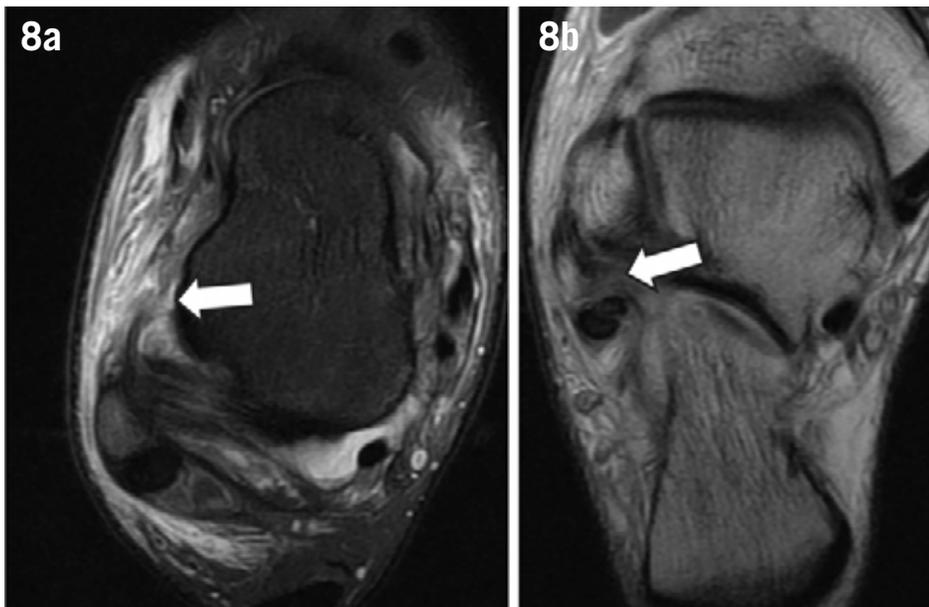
Magnetic resonance imaging of an injury affecting the lateral ligaments of the ankle. Axial T2 weighted image with fat saturation depicting a complete discontinuity of the anterior talofibular ligament near the talar attachment (arrow) and coronal oblique PD weighted image (b) depicting a nearly complete tear of the calcaneofibular ligament (arrow).
